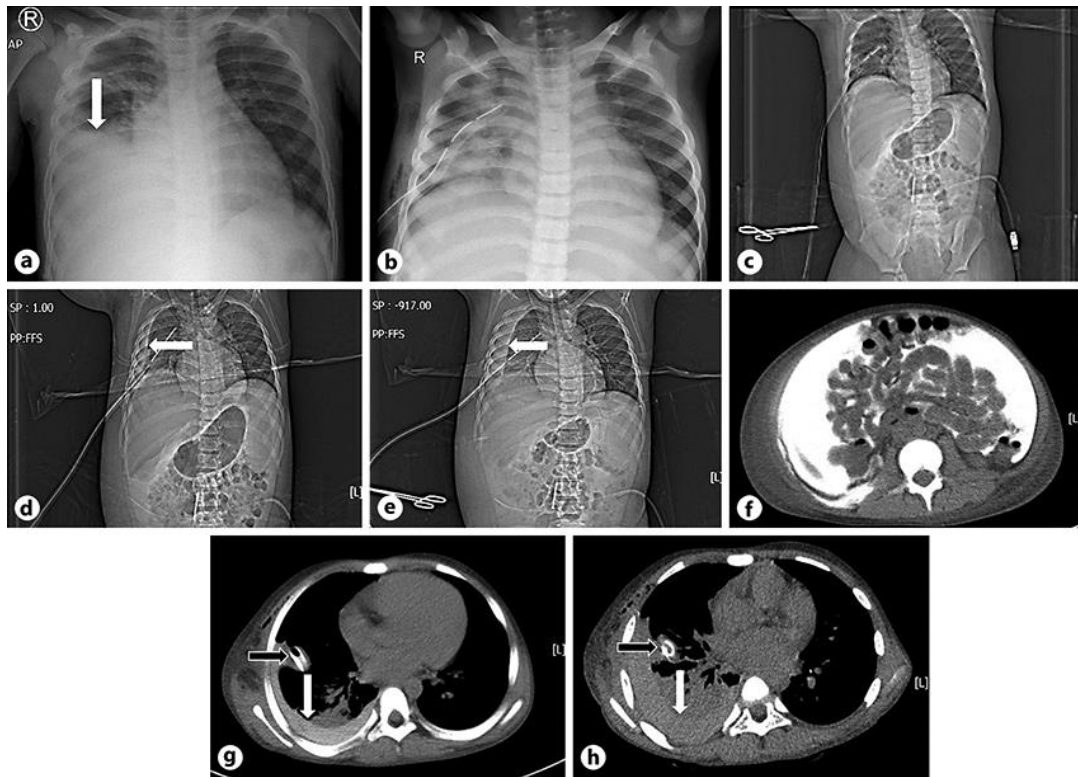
Imaging series of a 9-year-old male patient who experienced hydrothorax while on CAPD. a An initial chest radiograph showed right pleural effusion. b The pleural effusion resolved, and PD was performed with chest tube still attached. Note the presence of pneumonia. c Chest radiograph immediately prior to CT peritoneography. Chest radiograph shows increased presence of fluid in the right pleural cavity at the 30th min (d) and 180th min (e) (white arrows). f CT peritoneography of the peritoneum surrounded by peritoneal dialysis solution containing contrast media shows increased presence of fluid in the right pleural cavity at the 30th min (g) and 180th min (h) (white arrows), with black arrows indicating the position of the chest tube.
